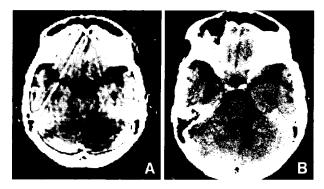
A: CT scan on the 3rd day shows low density of the bilateral cerebellar hemispheres, especially on the right. B: CT scan on the 15th day shows decreased low density.
